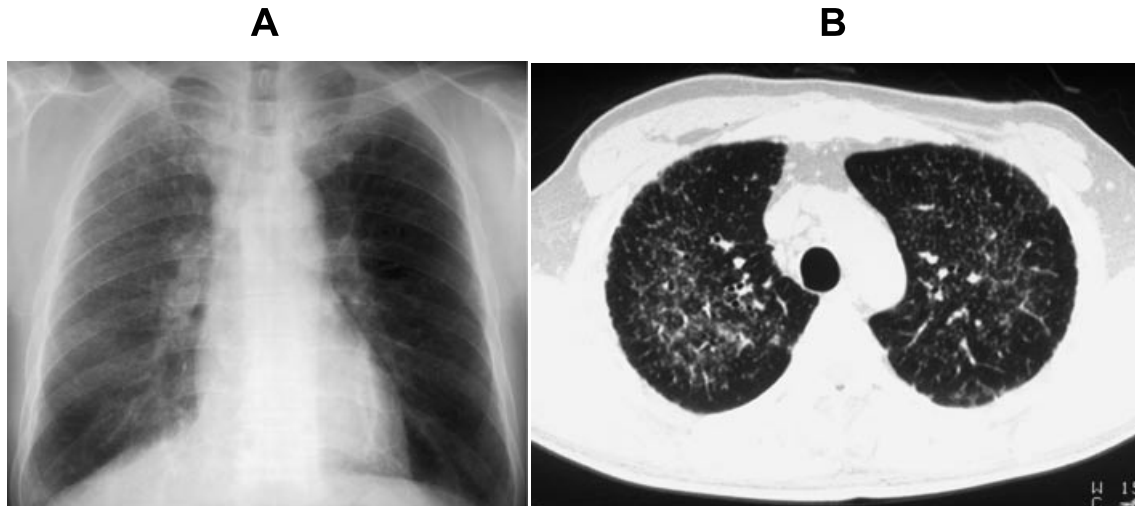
(A) A chest X-ray film on admission (March 16, 2001). Bilateral hilar lymphadenopathy and diffuse small nodular shadows in the bilateral lung fields were observed. (B) A Chest high resolution CT film on admission (March 19, 2001). Diffuse small nodular opacities oriented mainly in a centrilobular and peribronchovascular pattern and pleural nodules were seen.
